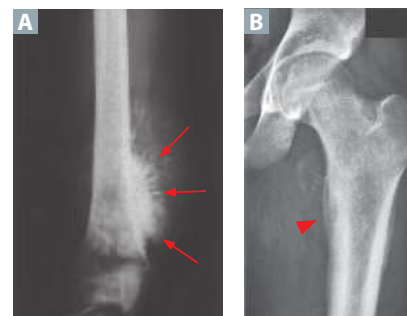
Malignant bone tumors. (A) Osteosarcoma. X-ray of the femur shows the typical “sunburst” appearance (arrows). (B) Ewing sarcoma. X-ray of the left hip shows characteristic “onion skinning” in proximal femur (arrowhead). (Reproduced with permission from Kantarjian HM, et al. *MD Anderson Manual of Medical*, 1st ed. New York, NY: McGraw-Hill; 2006.)
